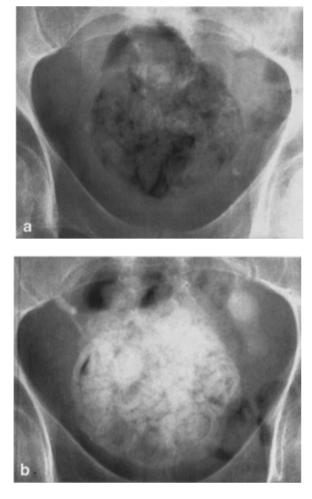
a,b. Fungus balls in the urinary bladder: a plain film; b after intravenous contrast
